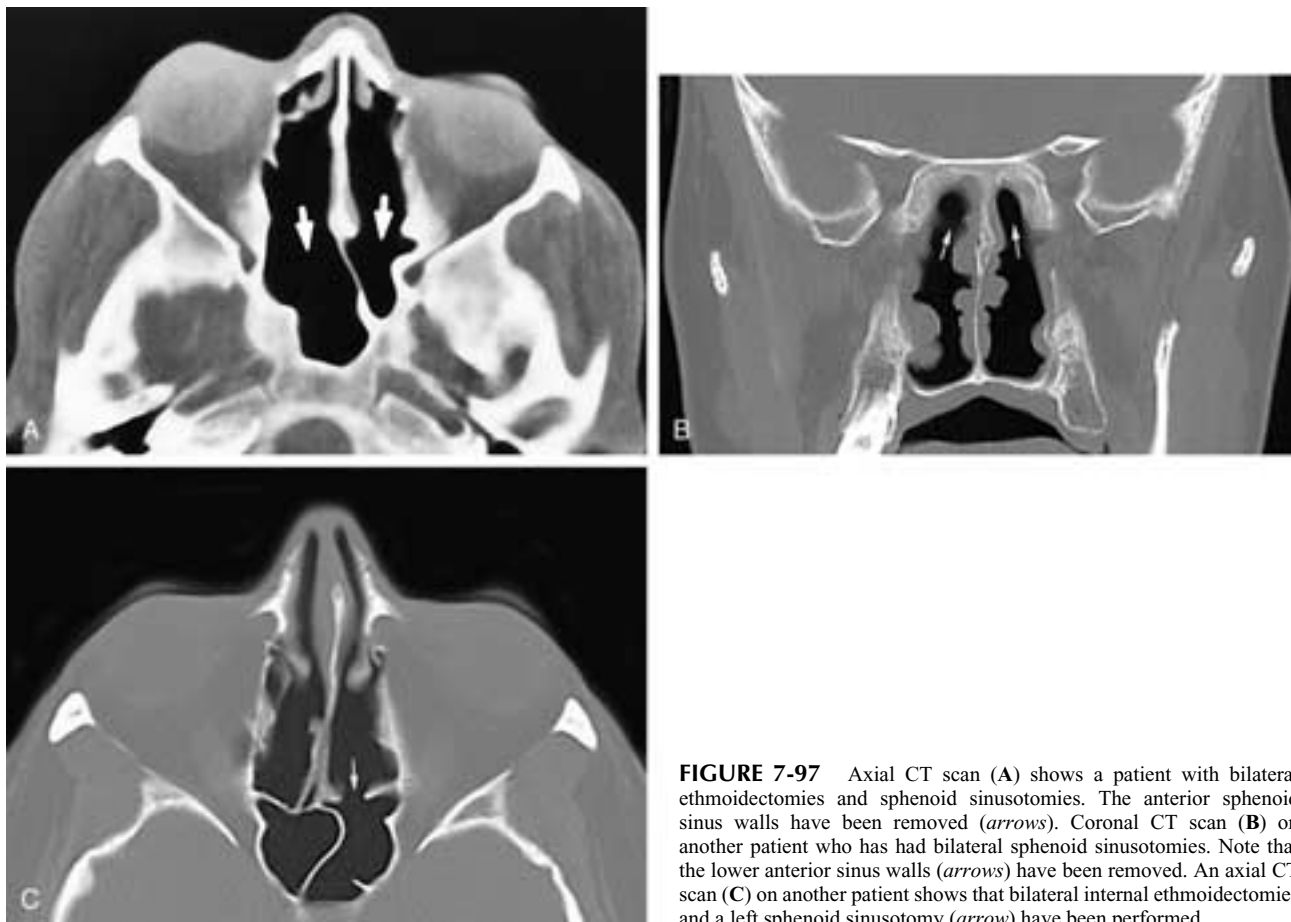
Axial CT scan (A) shows a patient with bilateral ethmoidectomies and sphenoid sinusotomies. The anterior sphenoid sinus walls have been removed (*arrows*). Coronal CT scan (B) on another patient who has had bilateral sphenoid sinusotomies. Note that the lower anterior sinus walls (*arrows*) have been removed. An axial CT scan (C) on another patient shows that bilateral internal ethmoidectomies and a left sphenoid sinusotomy (*arrow*) have been performed.
